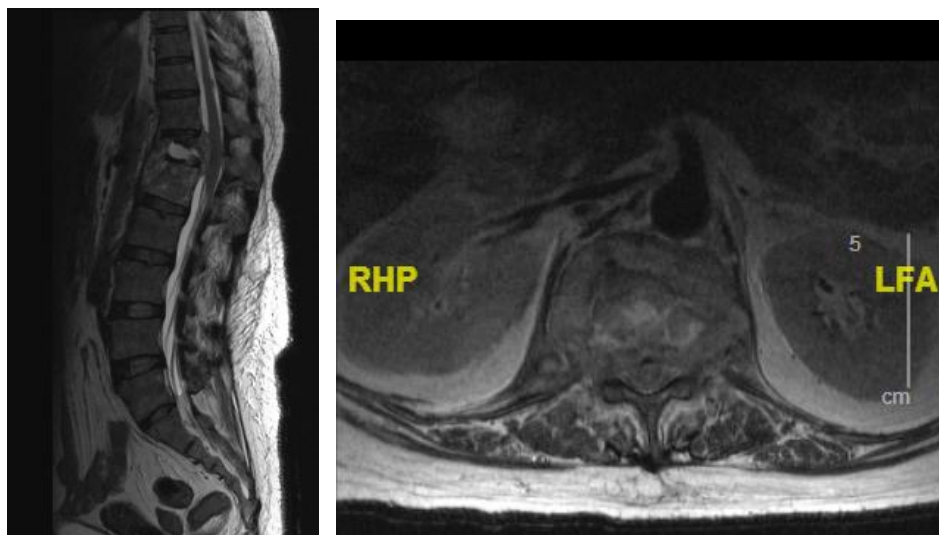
Lumbo-sacral MRI showing T12/L1 spondylodiscitis with spread into the epidural space, paravertebral space, and psoas, quadratus lumborum, and gluteus muscles.
